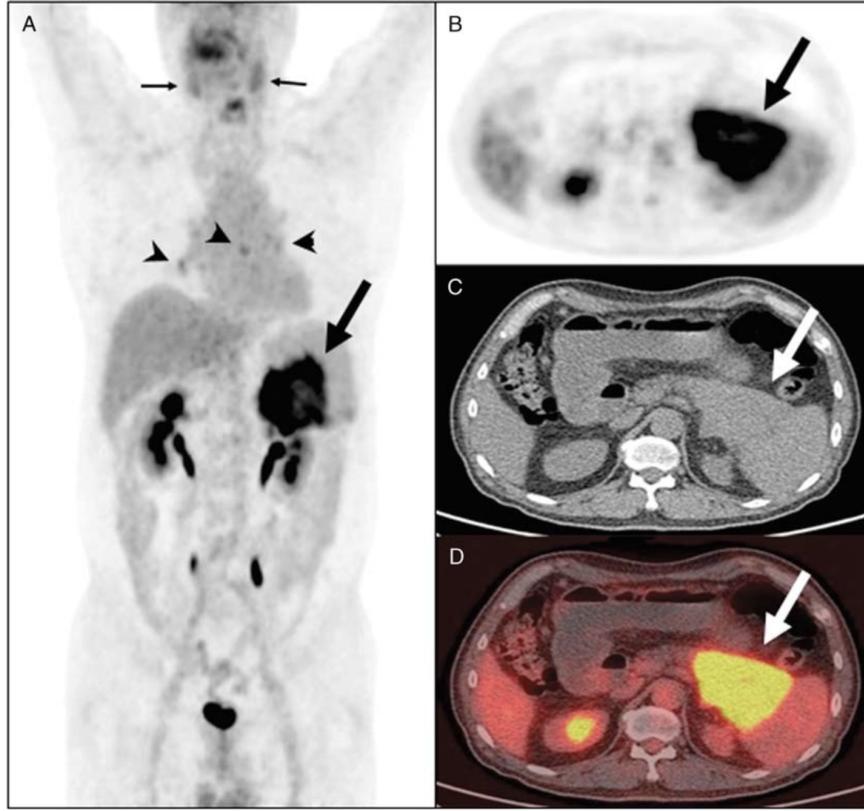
FDG-PET/CT imaging showing focal autoimmune pancreatitis mimicking pancreatic cancer. Note: the overlapping metabolic activity that challenges differentiation [38].
